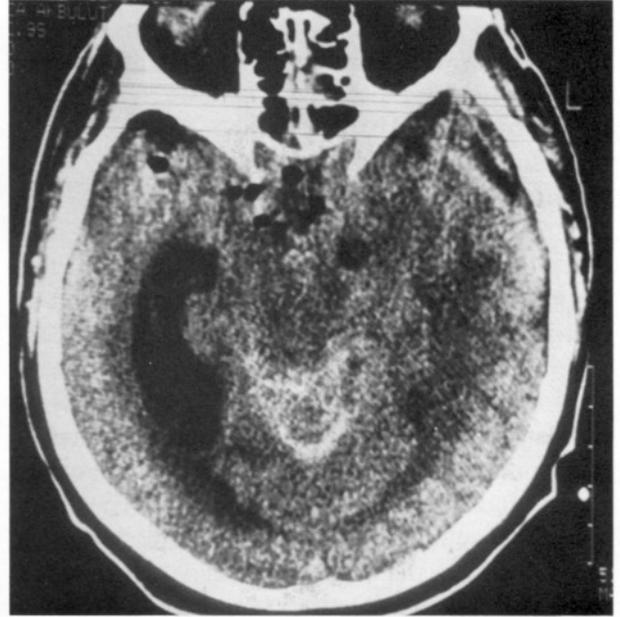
CT scan revealed a massive subarachnoid haemorrhage and also free air in the subarachnoid spaces as well as neurot parenchyma.
